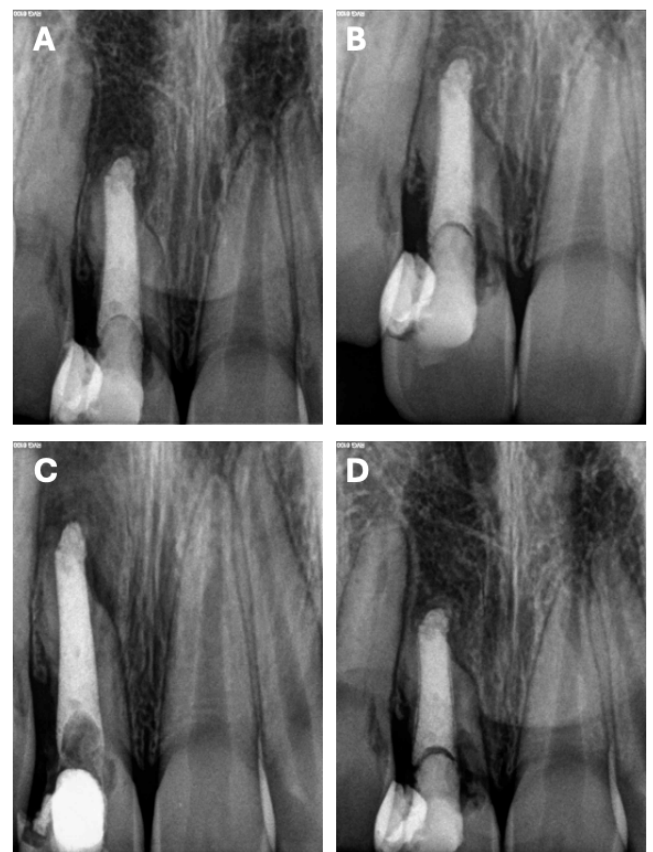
Clinical history of tooth #11. A: Postoperative periapical radiograph at 3 months after root canal treatment; B: Postoperative periapical radiograph at 8 months; C: Postoperative periapical radiograph at 10 months; D: Postoperative periapical radiograph at 14 months showing progression of EIRR and crown fracture
